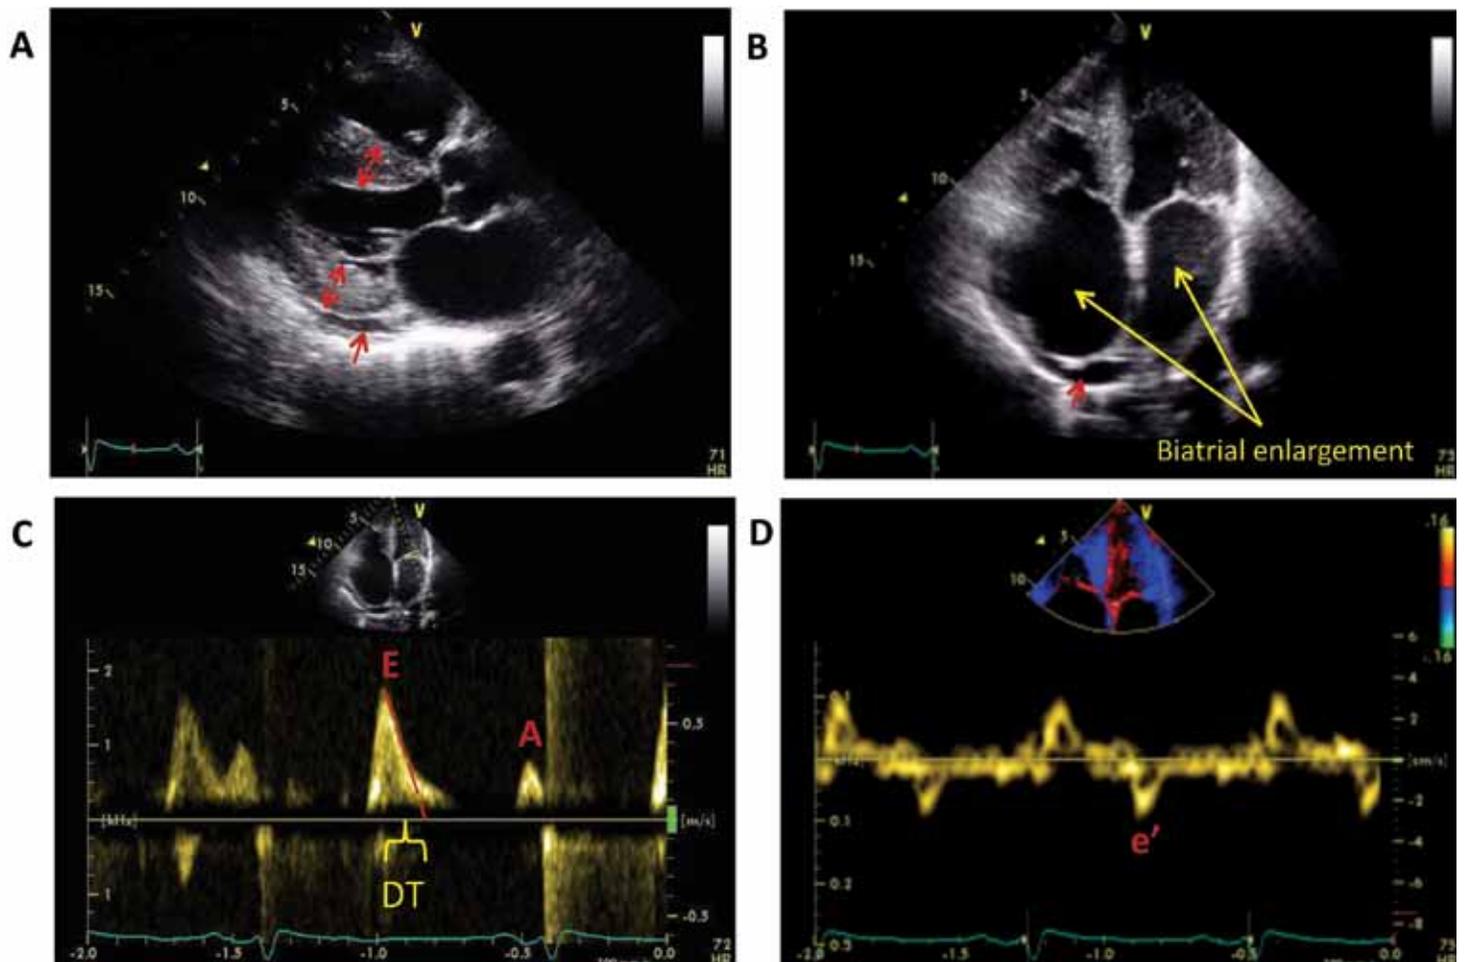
Echocardiographic features of advanced cardiac amyloidosis.
